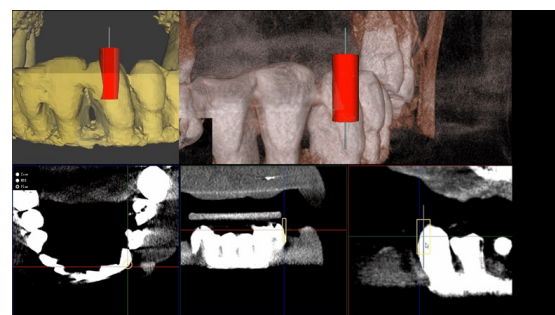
CT Image of the Dental Implant Placement
